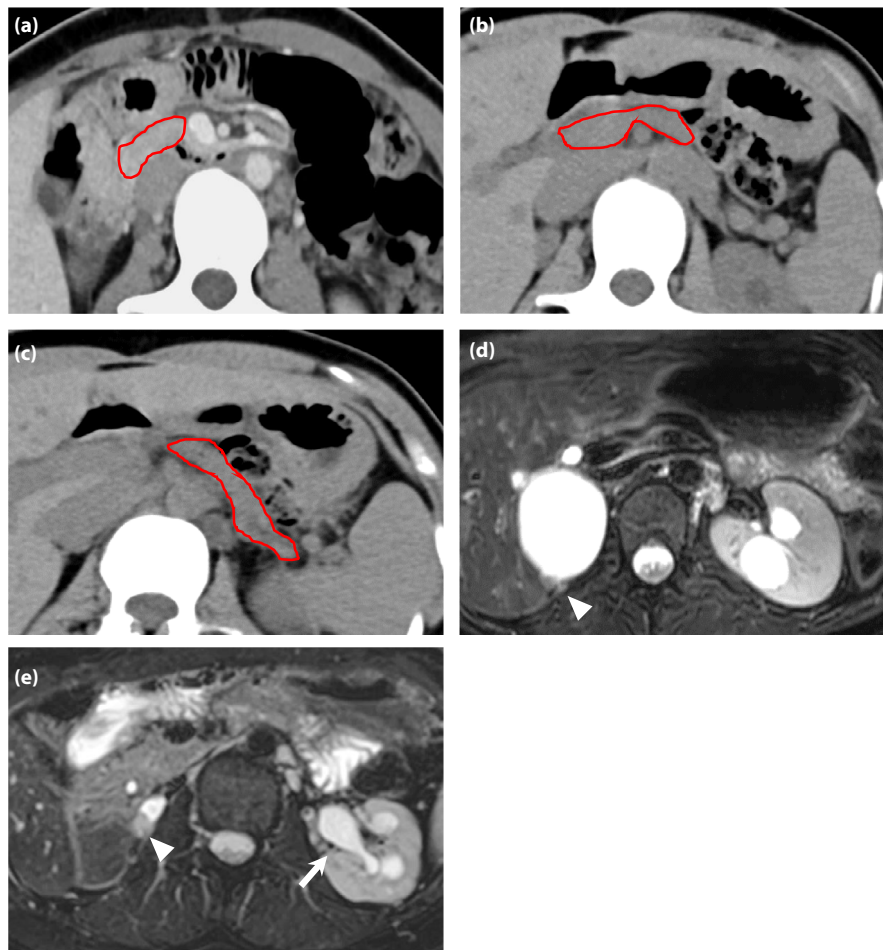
Abdominal computed tomography (a-c) and T2-weighted magnetic resonance imaging (d,e) for twin 1 (a,d) and twin 2 (b,c,e). The boundary of the pancreas is outlined in red (a-c). Computed tomography shows a small pancreatic head and complete deficiency of the pancreatic body and tail in twin 1 (a) as well as hypoplasia of the pancreatic body and tail in twin 2 (b,c). Arrowheads indicate marked aplasia of the right kidney and multiple bilateral renal cysts in both patients (d,e), and the arrow indicates hydronephrosis of the left kidney in twin 2 (e).
